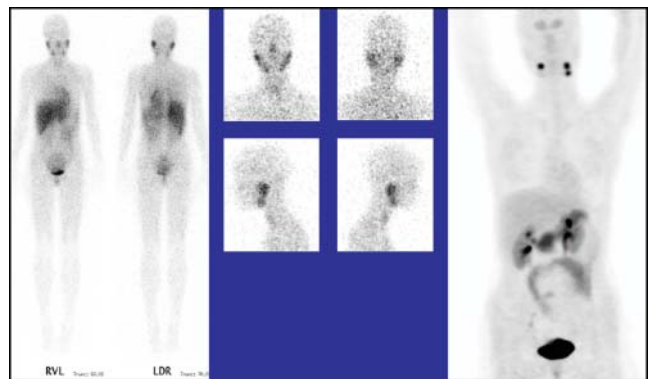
^{18}F -DOPA PET at 1 hour after injection (right) was superior to ^{123}I -MIBG scintigraphy at either 24 (left) or 48 hours (middle images) after injection in the pretherapeutic localization of multifocal paragangliomas.
